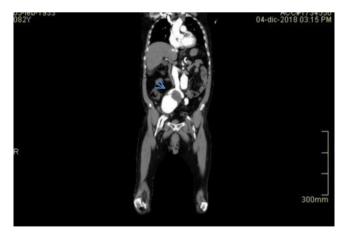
Computed tomography angiography (Axial view). Blue arrow is pointing to isolated aneurysm with contained rupture of the right iliac artery
